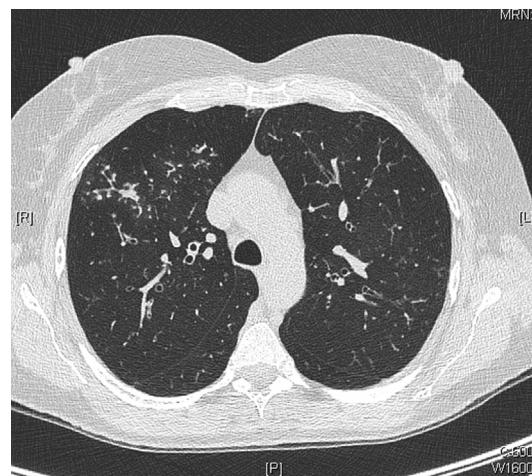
Chest CT of a patient with ABPA, showing tree-in-bud pattern.
